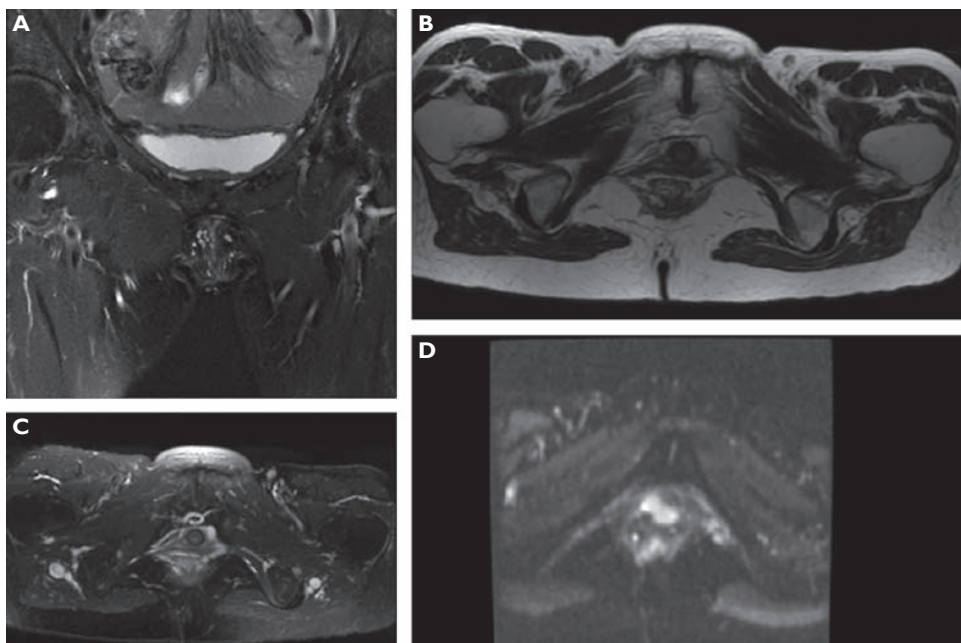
Magnetic resonance imaging sequences: A) coronal T2 PROPELLER fat-suppressed; B) axial T2; C) axial T1 fat-suppressed after contrasting medium administration; D) axial DWI (diffusion-weighted imaging) at high b-values with a small FOV (field of view). Examination revealed a lobulated, homogeneous lesion with intermediate SI (signal intensity) and maximum diameter of about 3.2 cm originating from the anterior wall of the vagina and extending and infiltrating the urethral meatus posteriorly and the levator muscles of the anus laterally.
